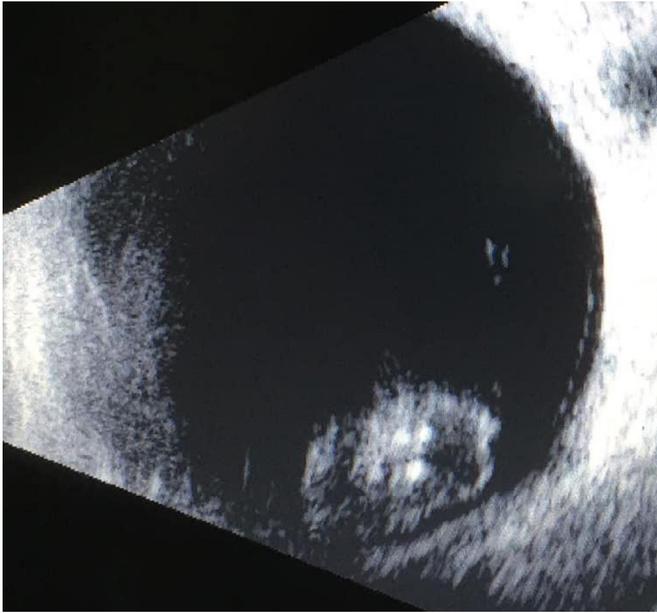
B-Mode ultrasonographic view of the crystalline lens.
